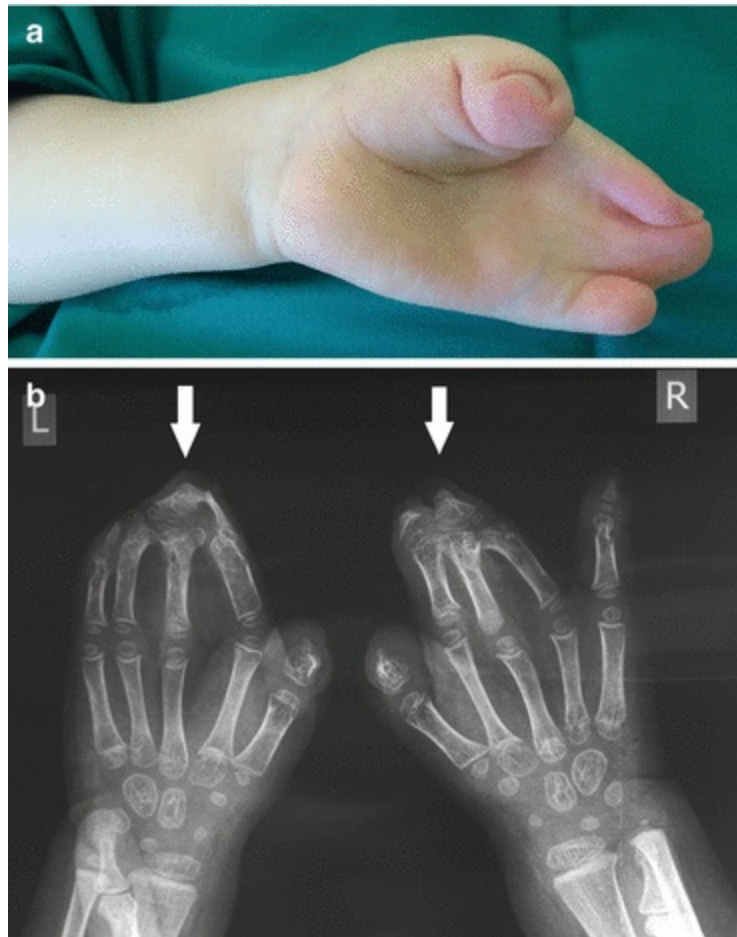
Complex syndactyly of the hand in Apert's syndrome: (a) clinical appearance; (b) radiography of both hands revealing fusion of distal bones
